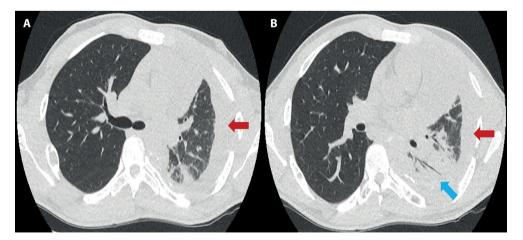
Chest CT scan, lung window. A, B. There is a loss of volume in the left hemithorax, left pleural effusion (red arrows), and infiltrates of alveolar occupation with consolidation of the apical segment of the left lower lobe (blue arrow).
